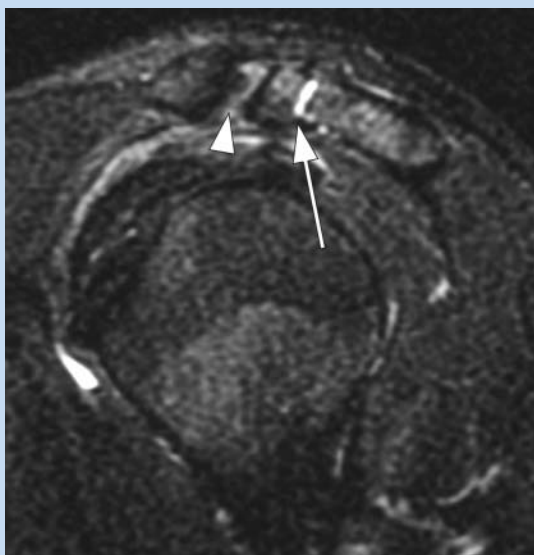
A fat-suppressed T2-weighted sagittal view in a patient with a symptomatic os acromiale reveals edema and fluid at and adjacent to the synchondrosis of the os (arrow). The more anteriorly located acromioclavicular joint is also visible on this sagittal slice (arrowhead), the "double-joint" appearance⁶ of an os acromiale.
